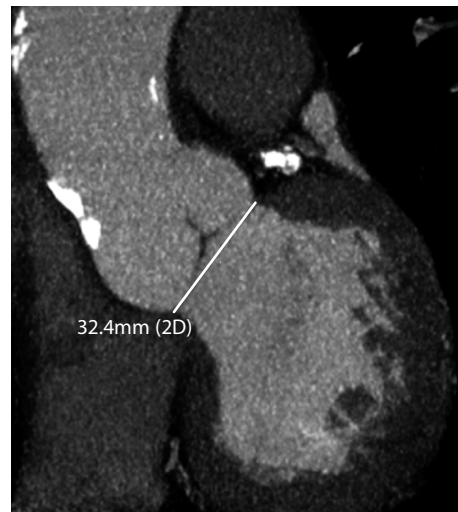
Visualization of the aortic valve based on a 16-slice CT examination. MPR perpendicular to the aortic valve annulus allows accurate preoperative assessment of aortic valve annulus diameter
